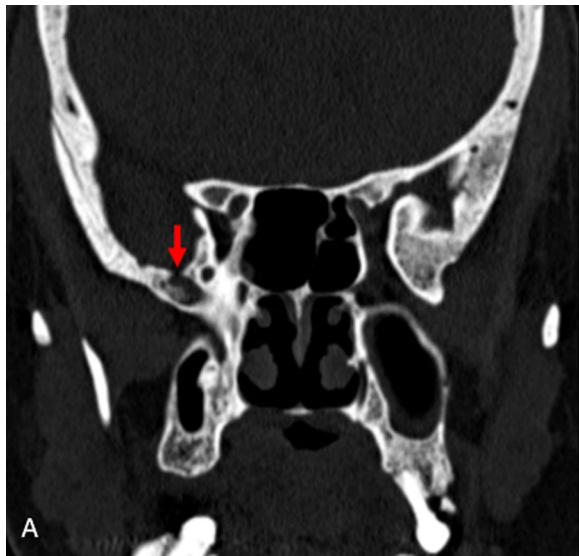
CT cisternography coronal section in bone window demonstrating the bony defect in the right greater wing of sphenoid bone (red arrow) and resultant contrast opacification (red arrow)
